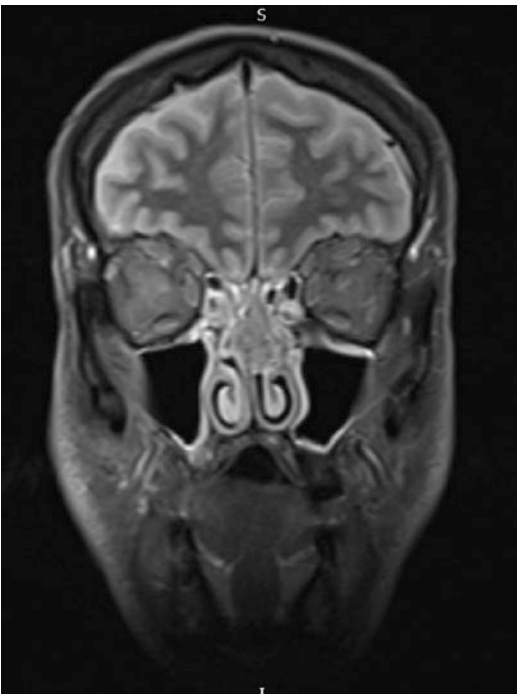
Gadolinium-enhanced MRI scan showing the mass involving the nasal septum
